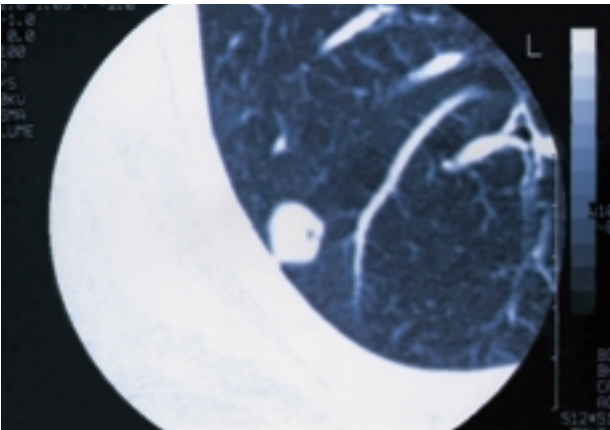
High-resolution computed tomography scan of the chest shows a small cavity in the subpleural nodule with spiculated margins in the right basal lateral segment.
